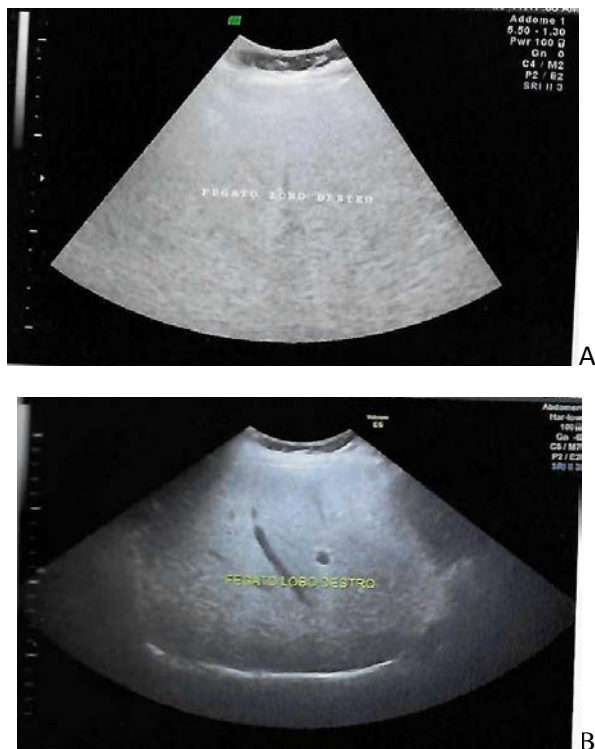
A) Ultrasound image of the liver before Olife® treatment; B) Ultrasound image of the liver after Olife® treatment. In Figure 2A, there is an increased echogenicity of the liver, a classic sonographic finding of hepatic steatosis. In Figure 2B, ultrasound image shows normal echogenicity of the liver parenchyma
